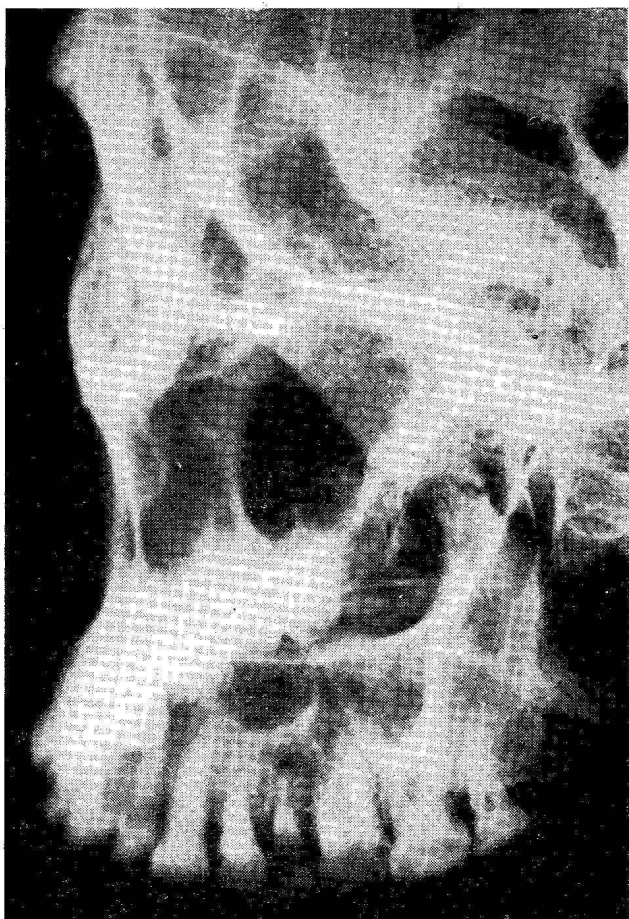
Roentgenogram of the same jaw, granuloma at the 2nd premolar and encapsulated cystic formation above it. Burial No. 93.
